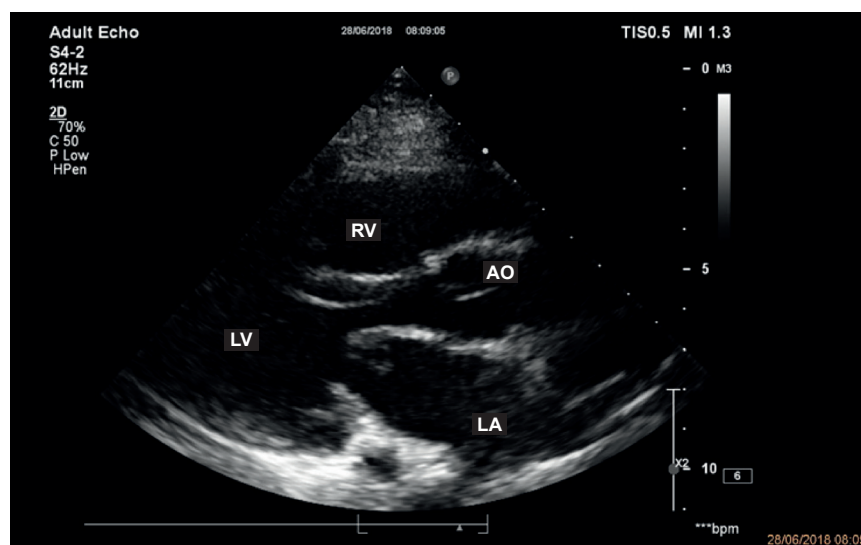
Parasternal longitudinal view evidencing mitral valve with thickening mainly at the tip of the cusps. RV: right ventricle; LV: left ventricle; AO: aorta; LA: left atrium.
